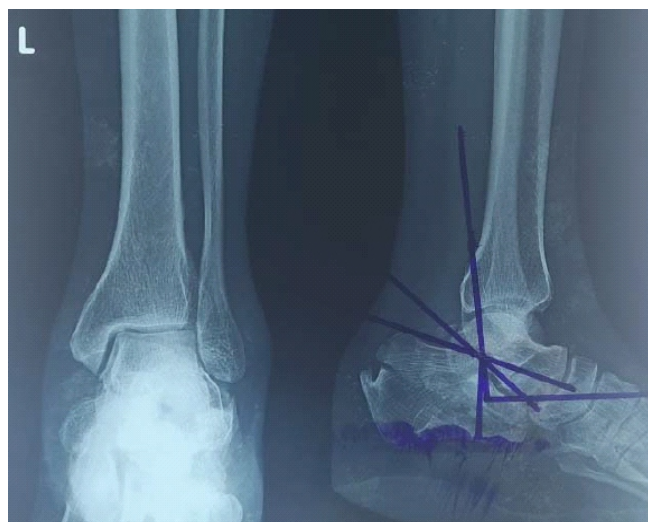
Initial pre-operative X-rays.
